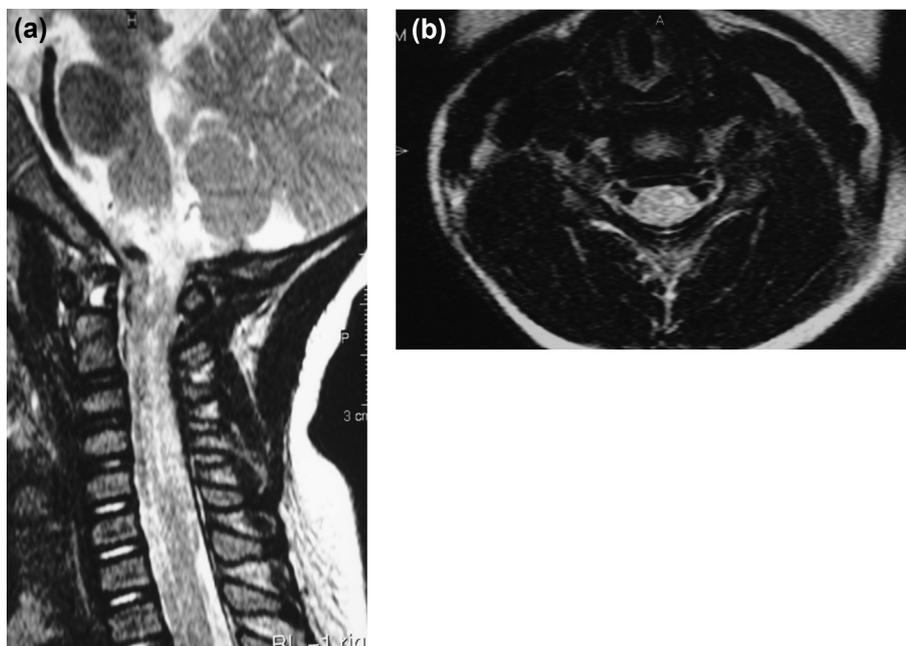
MRI of the spinal cord 6 months after onset. (a) T2W sagittal view. (b) T2W axial view at C4 level.
